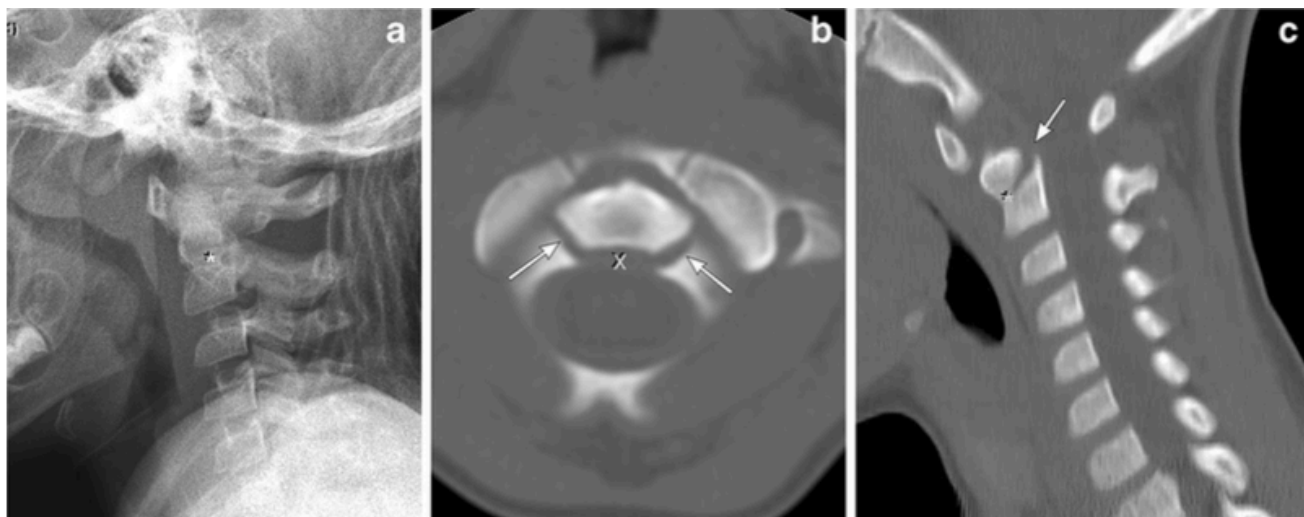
Type I subtype a fracture in patient 6, a 4-year-old boy with neck pain after trampoline injury. (a) Lateral radiograph (X-ray), (b) and axial CT and (c) sagittal (lateral view) CT images show fractures of the right and left odontoneural (arrows) and the odontocentral synchondroses (*) with <10% anterior displacement (x) and 13 deg. anterior angulation. This patient also had a T4 compression (collapse of the 4th thoracic vertebrae) fracture (not shown). He was treated with halo stabilization.
